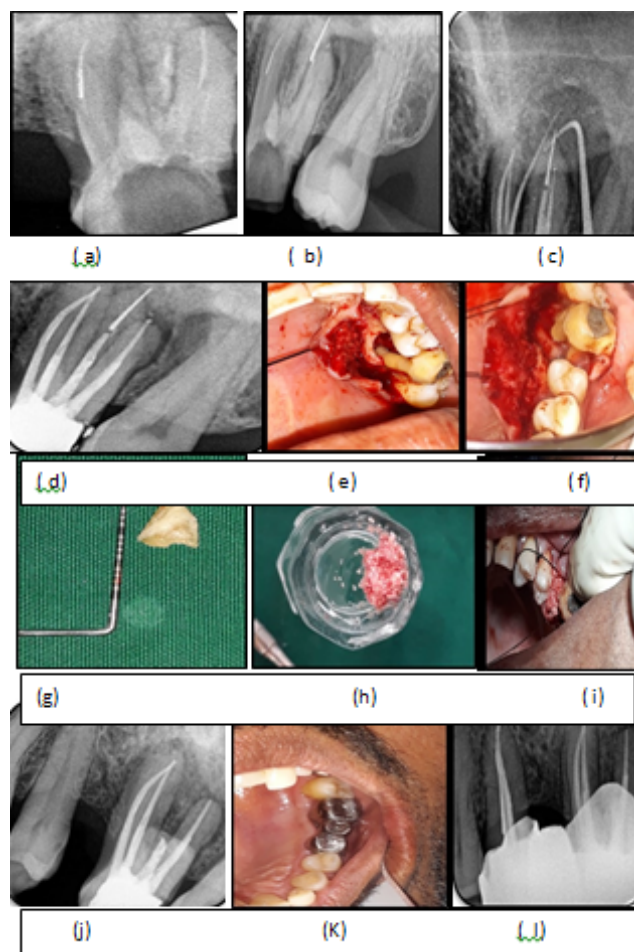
a) preoperative radiograph.(b)file separation with palatal root (c). sinus tracing (d). obturation (e) flap reflection and debridement.(f) after root resection.(g) amputated root with file(h) DMBM+PRF(i) sticky bone.(j)after 3 months (k)crown placement.(l)after 18 months.
